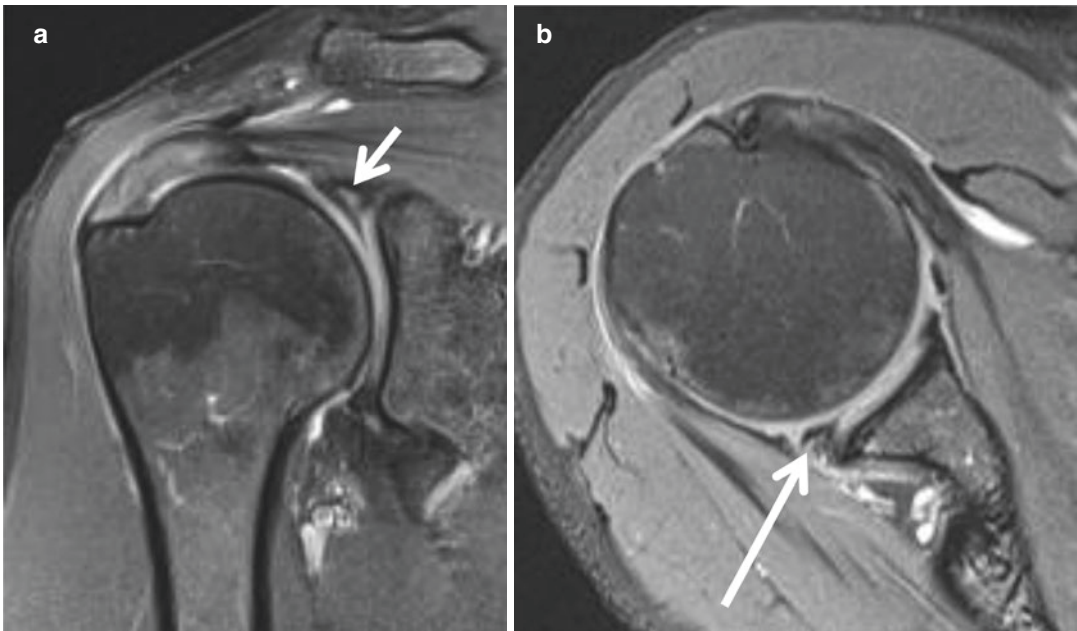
Labral tear. (a) Coronal oblique proton density fat-suppressed and (b) axial T2-weighted fat-suppressed images from the same patient demonstrating
